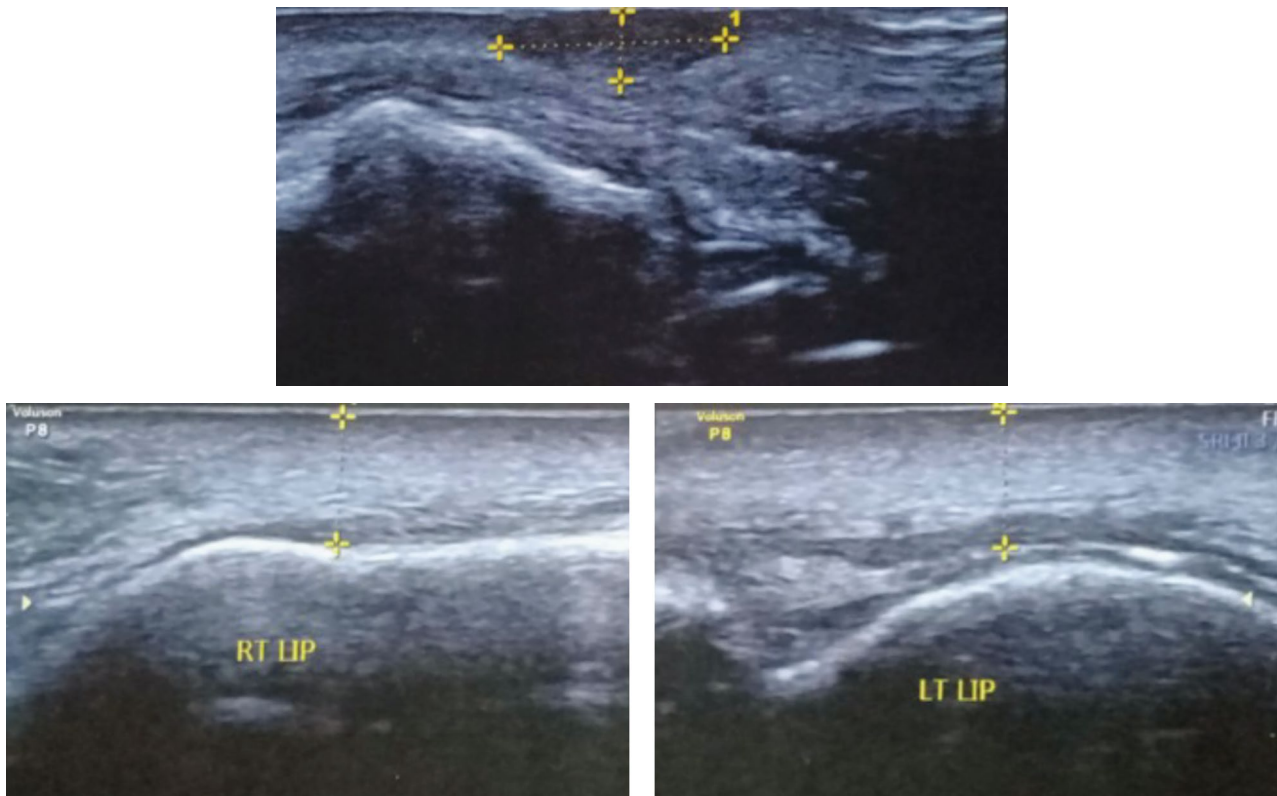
Ultrasound showing width of the lip scar, lip thickness on both sides of the scar.
